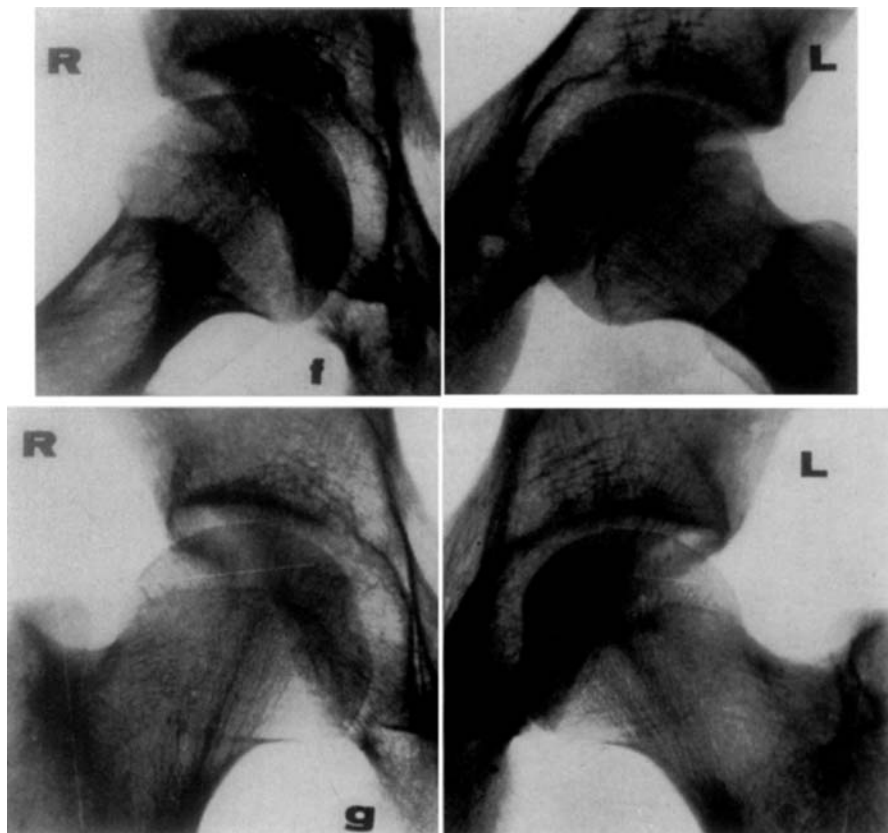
Case 46, boy aged 6 years and 10 months at onset. A large, oblique metaphyseal defect seen in *a* and *b* disappeared owing to reformation of bone at its margins, as seen in *c—e*. The epiphyseal line became regular. The radiographs *a—e* were taken from 10 to 34 months after onset, at intervals of 4 to 12 months, *f* and *g* about 10 years after onset. Treatment: Thomas' splint for 2 years and 9 months. End-result good.
